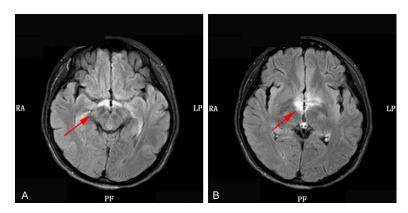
Typical MRI image cases. A, B: T2-weighted and FLAIR sequences of the brain MRI show bilateral optic tract damage with symmetrical hyperintense lesions around the third ventricle. Red arrows indicated hyperintense lesion area.
